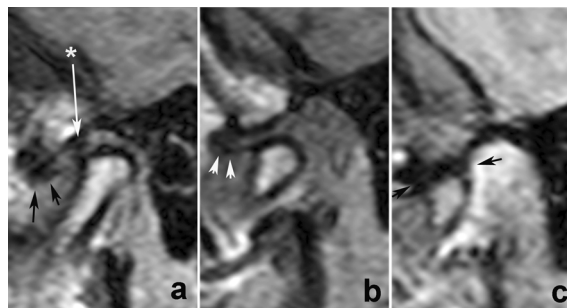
Follow-up examination of the left temporomandibular joint by magnetic resonance imaging in the position of habitual maximum intercuspitation (a), forced anterior position (b) and open mouth position (c). Note: disc displacement with reduction (arrows), and fibrosation of the retrodisc tissue (marked with *).
